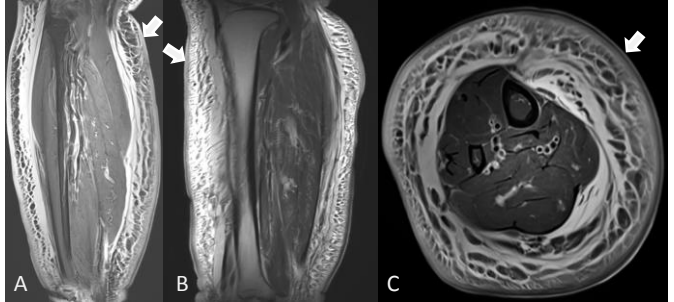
In right lower leg MRI on day of admission, fat-suppressed T2-weighted MRI Coronal view (A) Sagittal view (B) Axial view (C) showed subcutaneous edema with honeycomb pattern (arrows).
